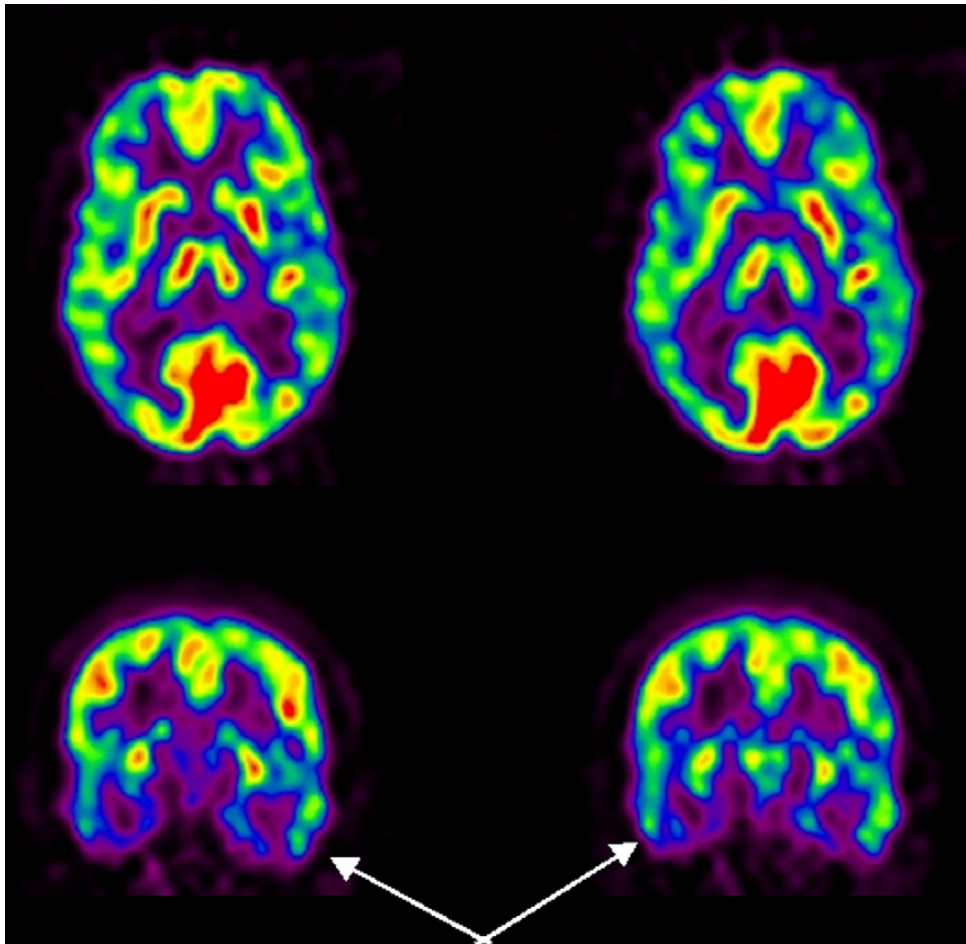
FDG-PET scan of patient with chronic cocaine abuse showing global cortical decrease in glucose metabolism, particularly in the temporal lobes (*arrows*).
